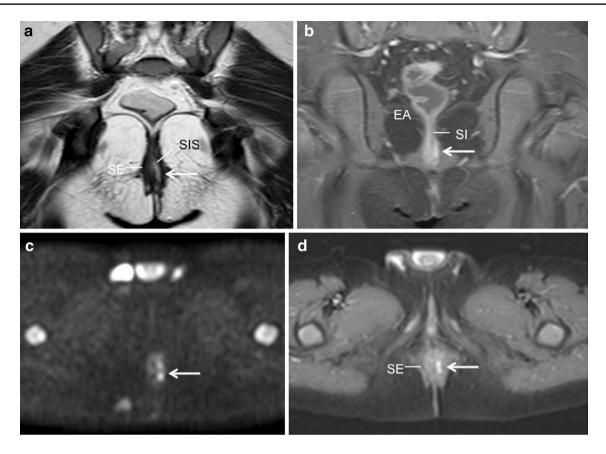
Grade 1 (Morris's) simple intersphincteric fistula which passes through the intersphincteric space (ISS). The fistula tract does not involve the external sphincter (SE) as evident in coronal T2-weighted image (a) and coronal short T1 inversion recovery (STIR) image (b). Axial diffusion-weighted whole-body imaging
